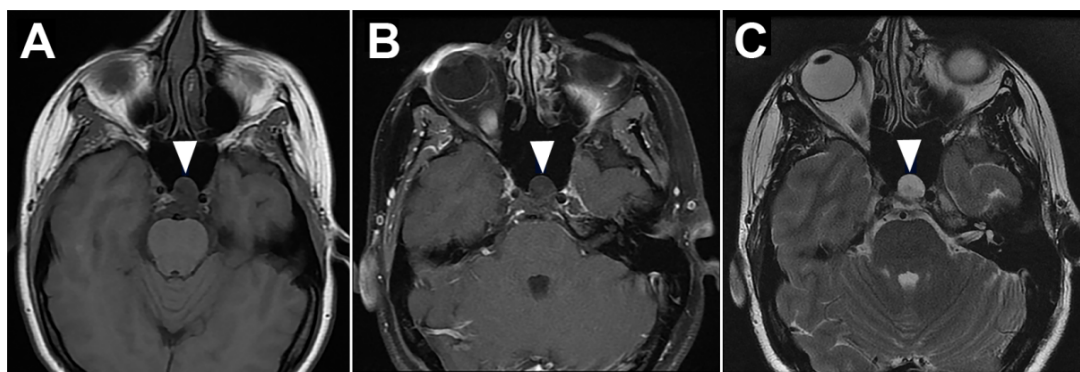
Magnetic resonance imaging of the patient's clival lesion, demonstrating extension into the sphenoid sinus (arrowhead). (A) T1-weighted axial image taken without contrast revealing a hypointense lesion. (B) Gadolinium-enhanced T1-weighted axial image revealing no contrast enhancement. (C) T2-weighted axial image revealing a hyperintense lesion.
